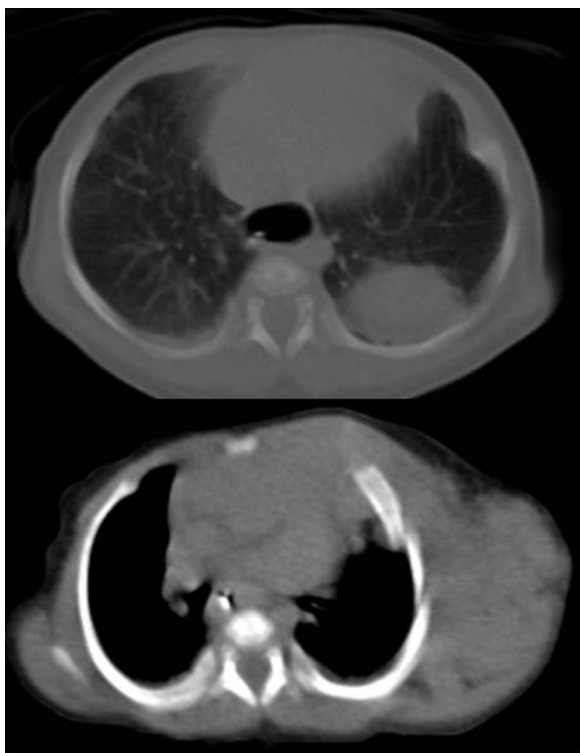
Thoracic CT scan showing three nodular lesions on the left pulmonary parenchyma, the larger with 34 mm and located on the rear side of the lung.
